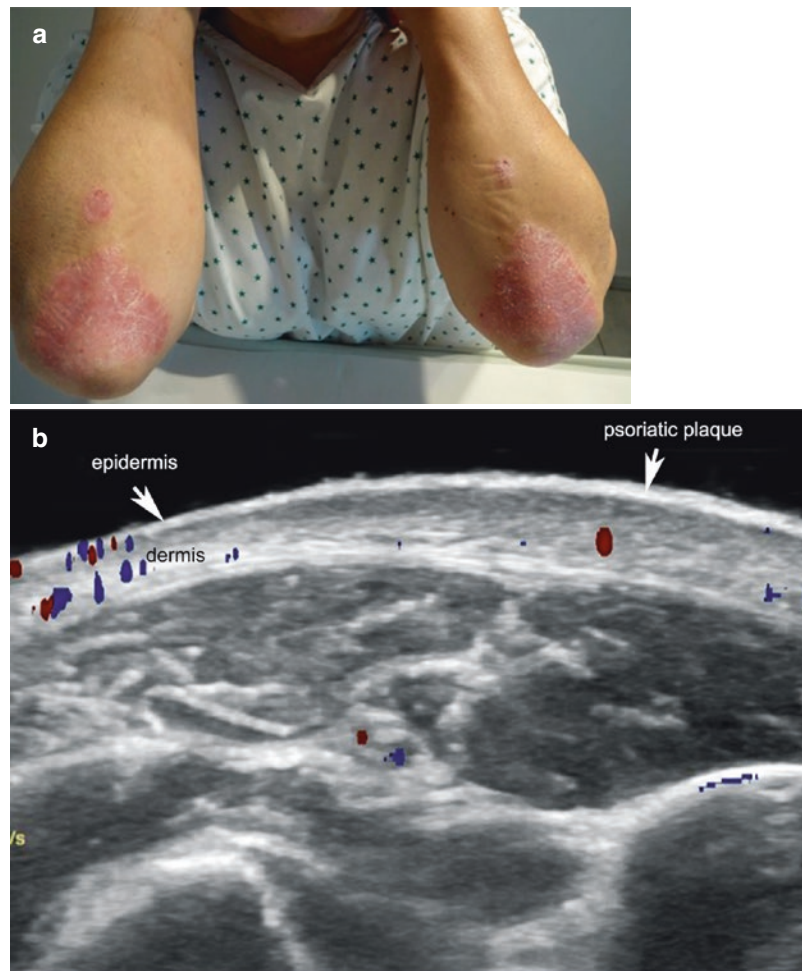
Active psoriasis with skin, tendon, and bone involvement. (a) Clinical image. (b) Color Doppler ultrasound (transverse view, proximal part of the left forearm) shows epidermal and dermal thickening with dermal hypoechogenicity and hypervascularity. (c) Ultrasound
